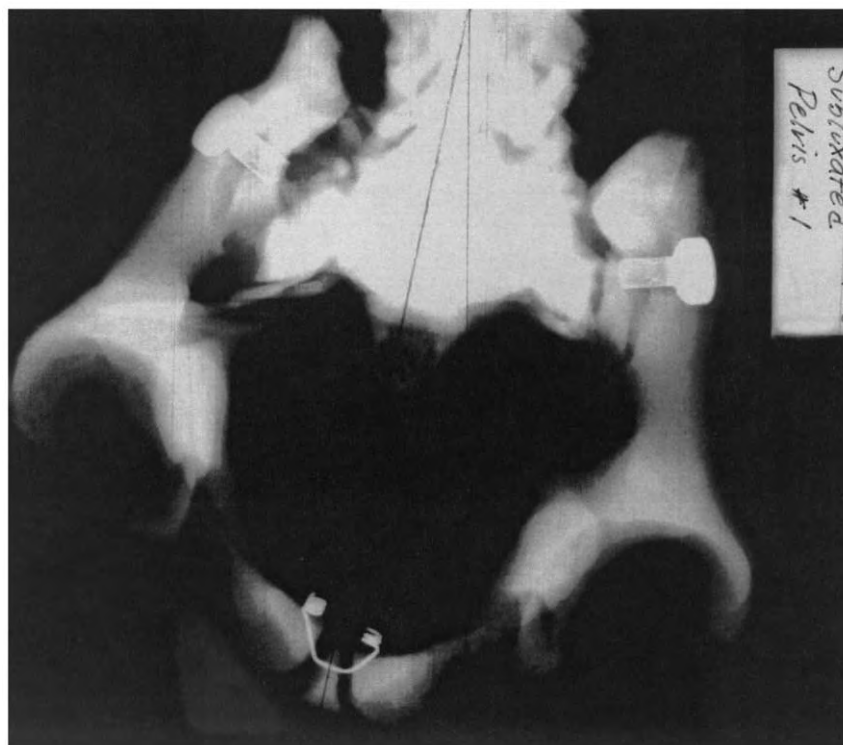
PI/anterosuperiorly subluxated female pelvic bowl. (Model) S to I view. Note lack of symmetry and distortion of roundness of opening. Also note difference in space from centerline through pubic symphysis. (Radiograph provided courtesy of Cherie Goble, DC.)
